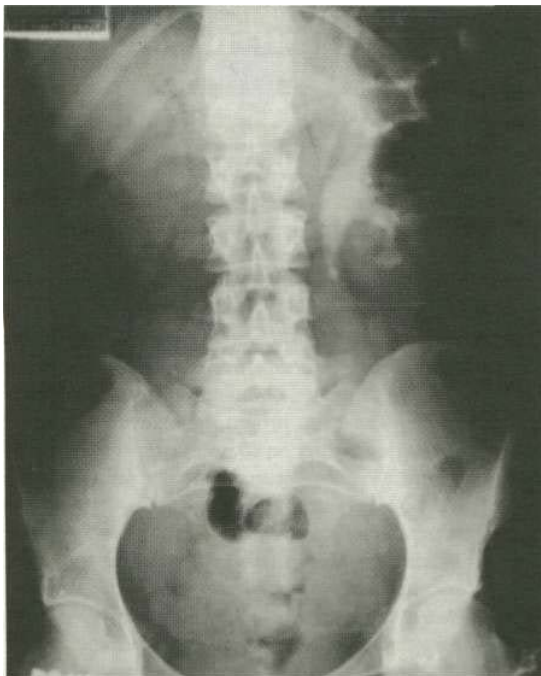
X-ray taken 24 hours after injection of contrast, showing a delayed nephrogram and pyelogram on the left side and dilatation of the system to the level of the block. By this time contrast medium has disappeared from the normal right side.
